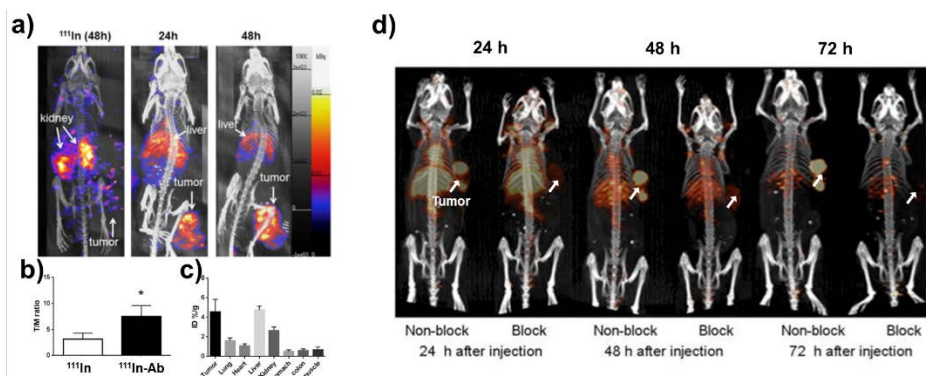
In vivo nuclear medicine imaging of radiolabeled antibody. a) In vivo PSECT /CT imaging of ^{111}In and ^{111}In labeled antibody (^{111}In -Ab). b) Tumor to muscle ratio comparison between free ^{111}In and ^{111}In -Ab. c) Quantitative analysis of ^{111}In -Ab in major organs and tumor. White arrows are indicated liver, kidney, and tumor, respectively (reproduced from Shih, et al.)⁹⁰. d) In vivo PET imaging of ^{64}Cu labeled antibodies with and without blocking at various time points (24, 48, and 72 h) (reproduced from Guo, et al.)⁹¹.
